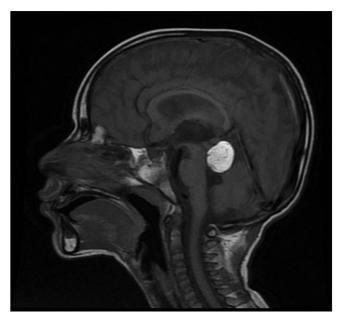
Magnetic resonance imaging of the brain after 2 months of follow-up demonstrating no change in size (2.5 cm \times 1.9 cm \times 1.6 cm) or characteristics of the quadrigeminal cistern lipoma in T1 sagittal series.
